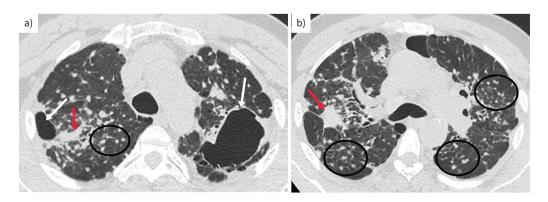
Chest computed tomography post-tuberculosis treatment dated 15 October 2013 (same patient as in figure 1). Selected axial images at the a) mid-thoracic tracheal level and b) tracheal carina show residual thin-walled cavities bilaterally, the left larger and visible on the chest radiographs. The background numerous small (<10 mm) nodular opacities are clustered and predominantly posterior (black ovals) and typical in location for silicotic nodules. Additionally there are multiple nodules studded along the pleural surface, also a typical location for silicotic nodules which are mainly perilymphatic in contrast to TB nodules which are bronchocentric. The larger (>10 mm) opacities are indicated by red arrows, image b) showing the peripheral para-cicatricial emphysema indicated by white arrows in image a) which is also a typical finding in patients with progressive massive fibrosis. b) Reproduced from [33] with permission.
